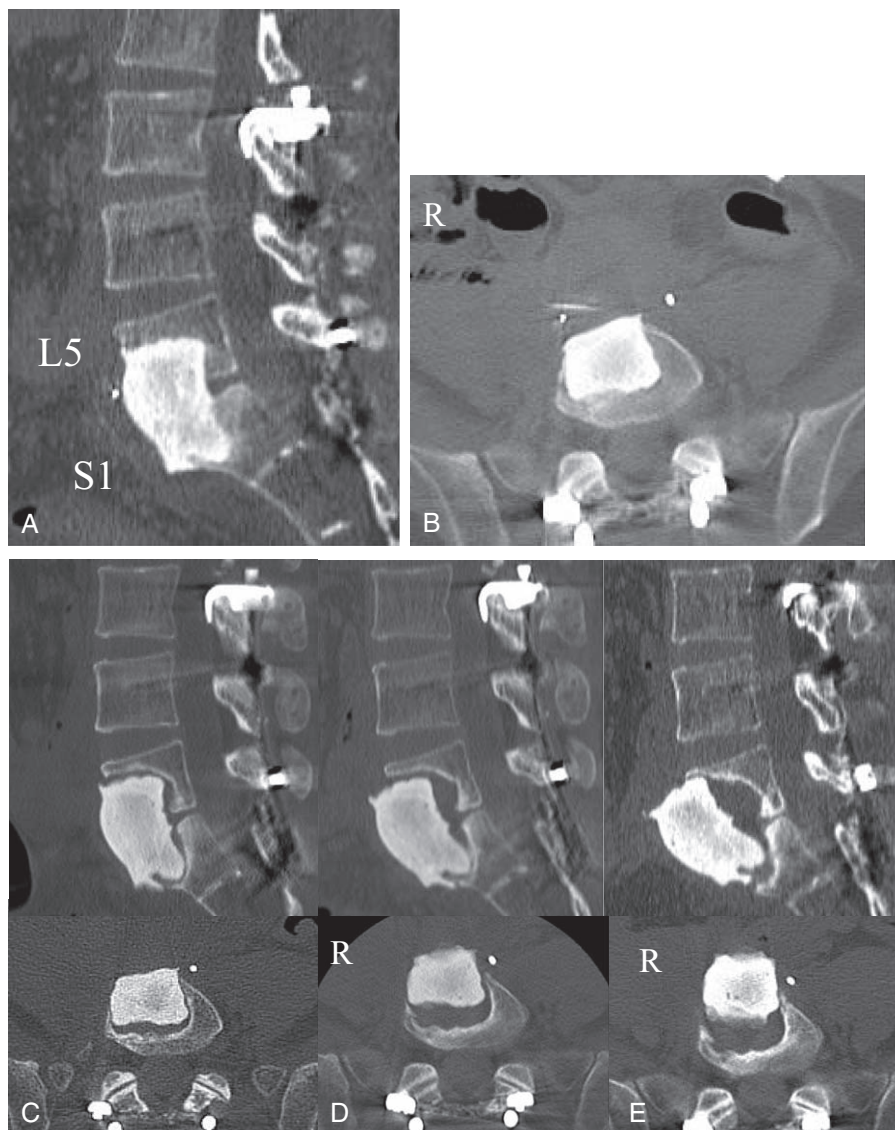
Postoperative plain radiographs. After posterior lumbosacral fixation, the tumor was resected and PMMA cement was used for vertebral body reconstruction. Plain radiographs show immediate postoperative (A, B) and postoperative 7 months (C), 27 months (D), and 33 months (E). Over time, the PMMA cement can be seen to move in an anterior direction, and 33 months after surgery, it had dislodged into the retroperitoneum. PMMA = polymethylmethacrylate.
